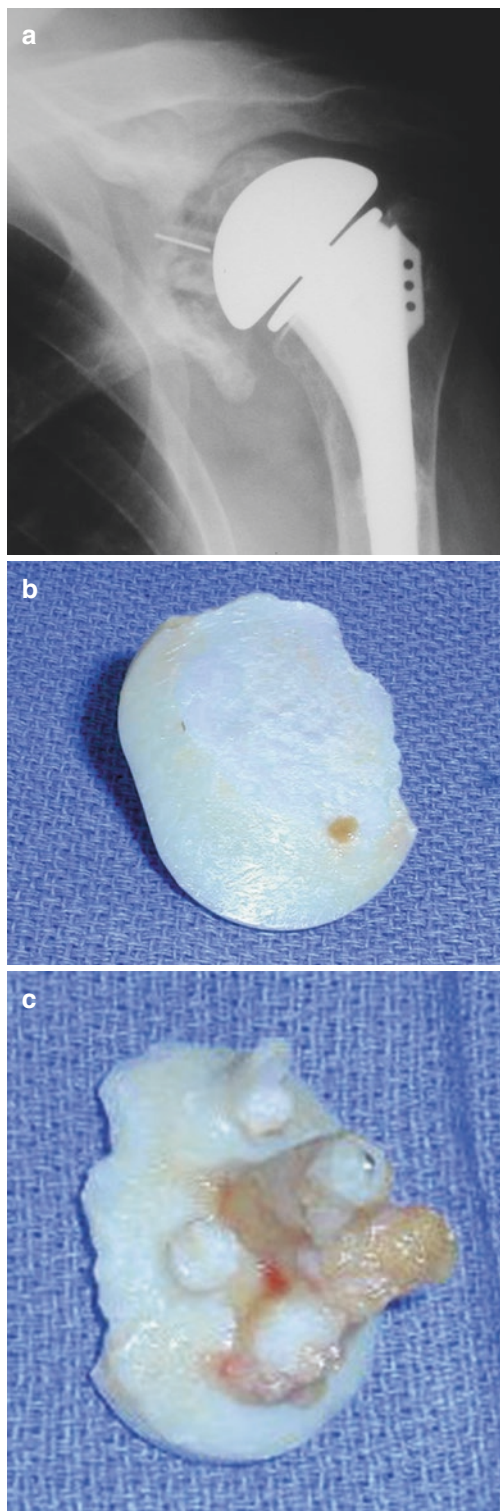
Failed all-polyethylene glenoid. AP radiograph (a) demonstrating a loose glenoid component. Glenoid component showing posterior superior wear after removal including articulating surface (b) and backside (c)
